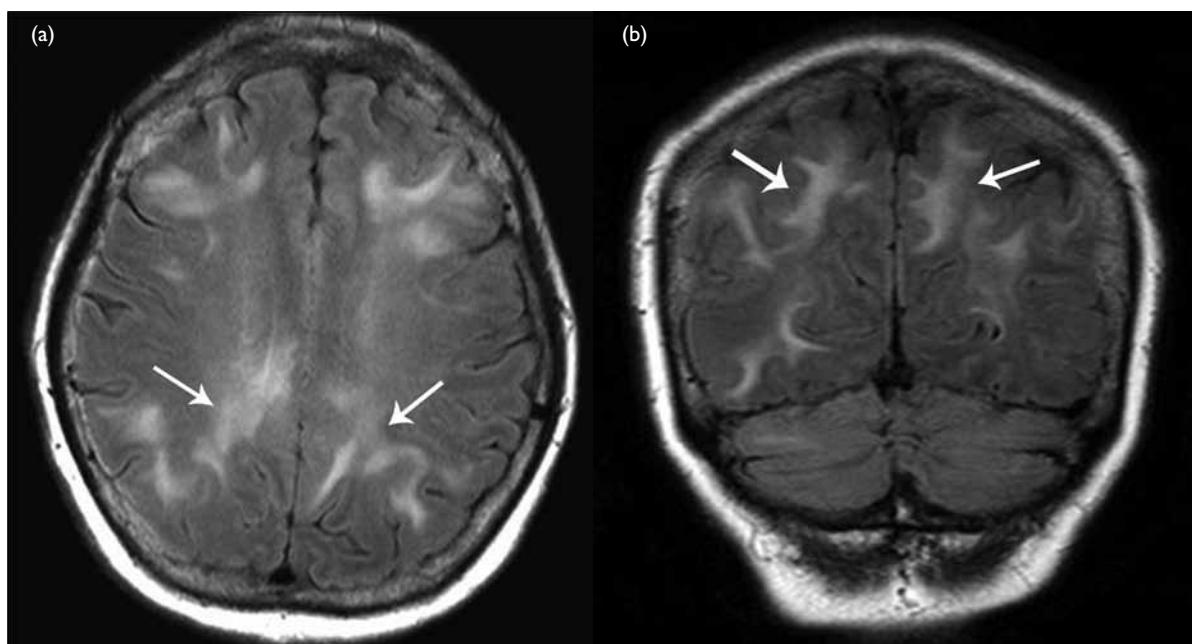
Magnetic resonance images of the brain showing multiple symmetrical T2-weighted signal abnormalities in the subcortical white matter (arrows) in the posteroinferior parietotemporal lobes: (a) transverse plane and (b) coronal plane
